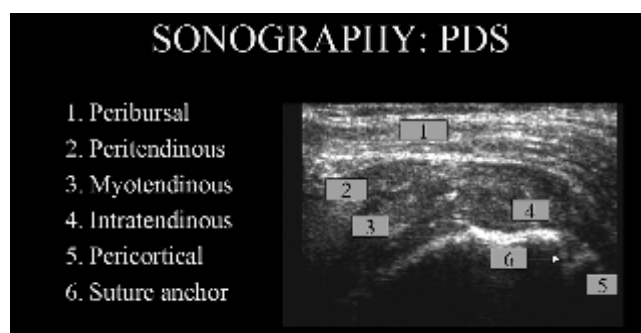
Power Doppler analysis consisted of examining several portions of the repair. The peribursal (1), peritendinous (2), musculotendinous (3), intratendinous (4), pericortical (5), and site of the suture anchor (6) were visualized for all patients at each time point postoperatively.
